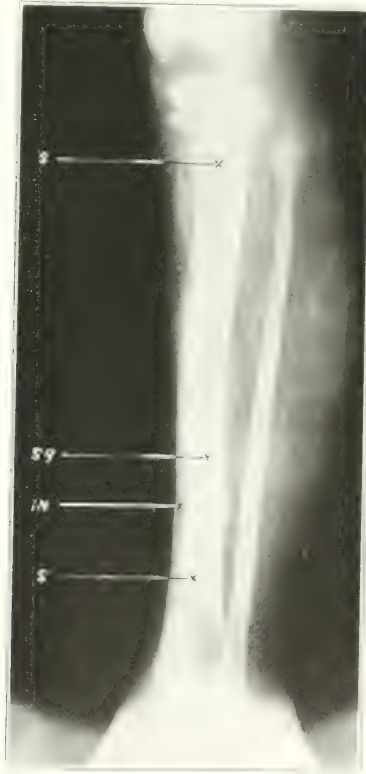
(Case 2).—Roentgenogram taken, Dec. 8, 1919, previous to operation: *Sq*, sequestrum; *In*, involucrum; *S*, separation zone.
